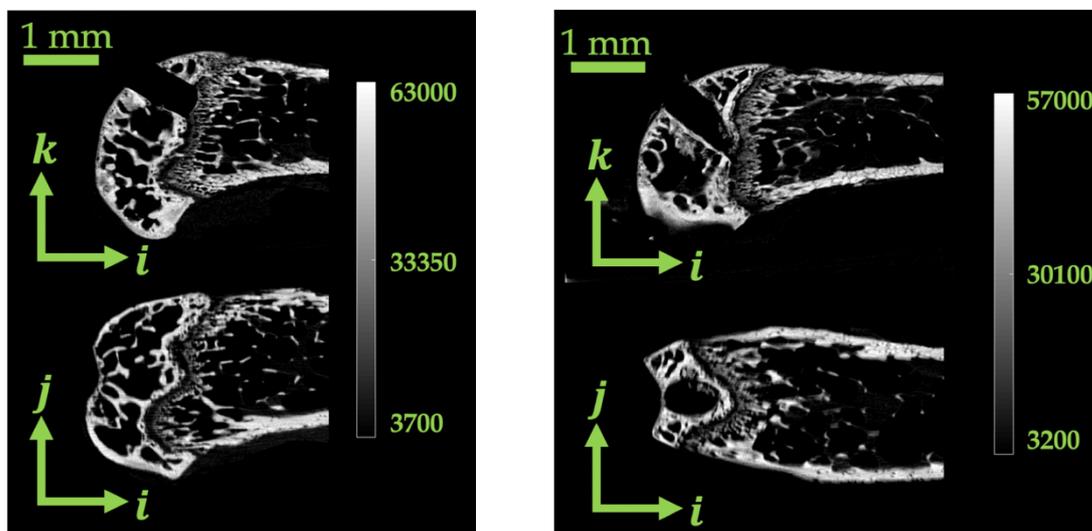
CT scans of drilled hole (left) and needle hole (right)
